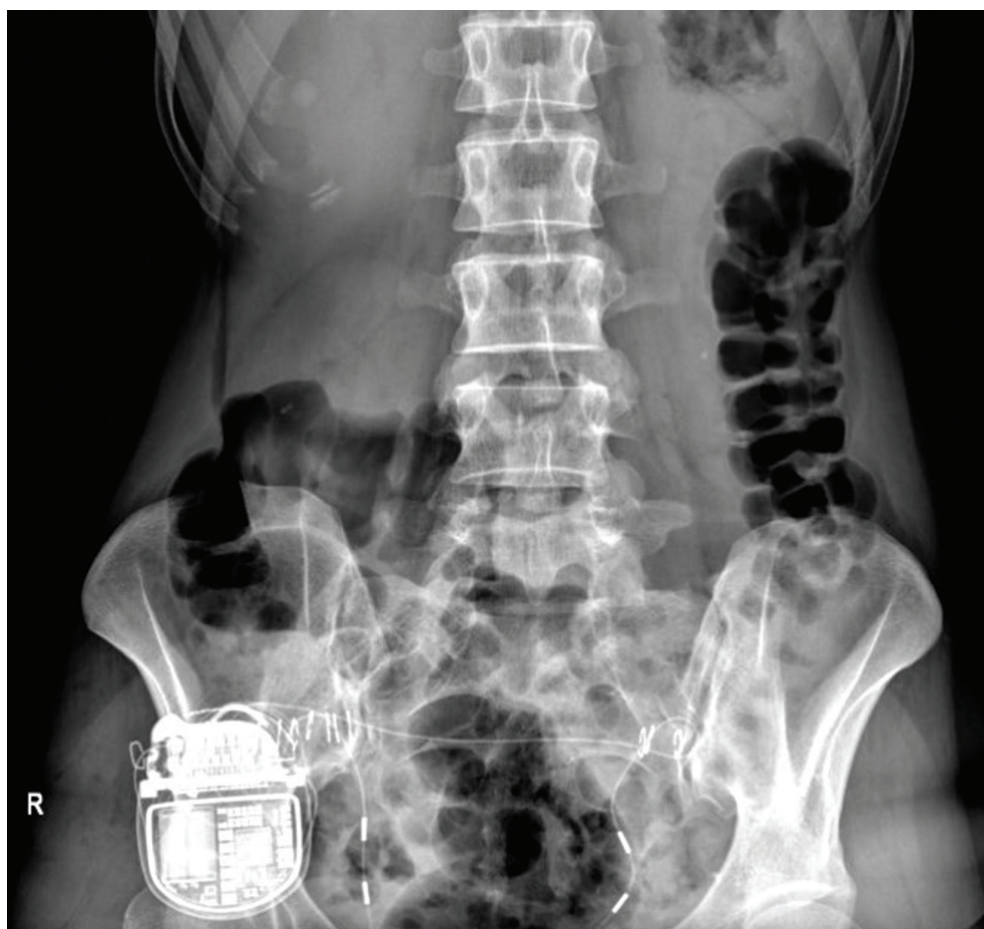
The implanted peripheral nerve field stimulation system of our patient (postoperative anteroposterior X-ray).
